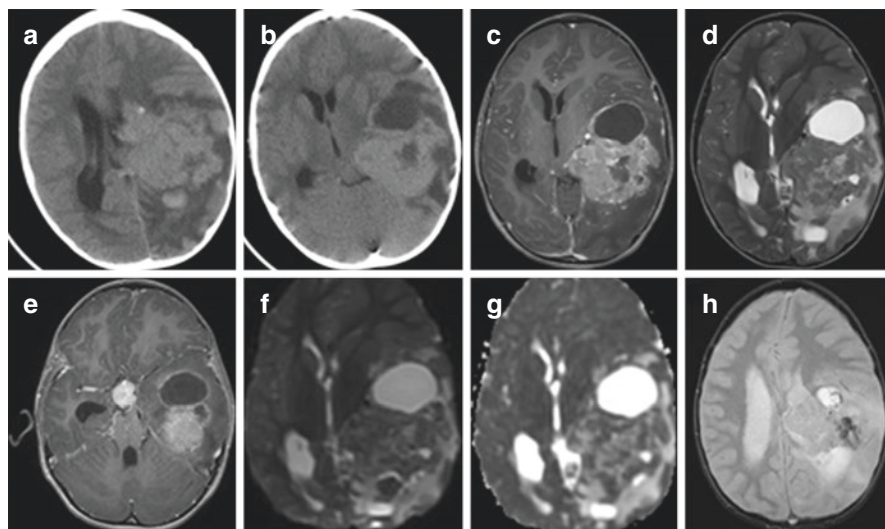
Neuroimaging of Choroid Plexus Carcinoma. (Patient example from our own institution, Neurosurgical Service, KK Women's and Children's Hospital). Large lesion arising from the choroid plexus of the left lateral ventricle with lobulated appearance, cystic changes, and internal calcification with brain invasion. There is also suggestion of dissemination into the suprasellar cistern and hydrocephalus. (a and b): Axial CT image at the level of ventricular atrium and 3rd ventricle; (c) Axial T1W + C image at the level of the 3rd ventricle; (d) Axial T2W image; (e) T1W + C image at the level of suprasellar cistern; (f) Axial DWI; (g) Axial ADC image; (h) Axial GRE image. (CT: computed tomography; T1W + C: T1 weighted image with contrast; DWI: diffusion weighted image; ADC: apparent diffusion coefficient; GRE: gradient echo)
